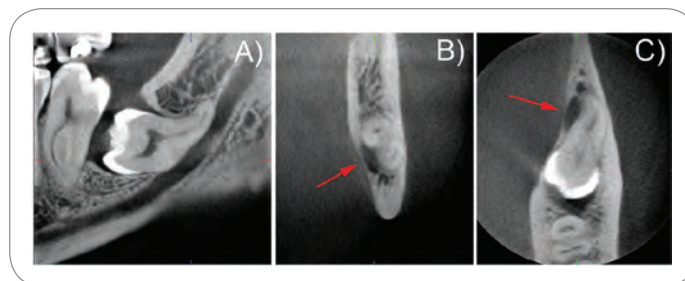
Sagittal (A), cross-sectional (B), and axial (C) CBCT sections of impacted tooth No. 17. Red arrow points to the lingual position of the inferior alveolar canal.
